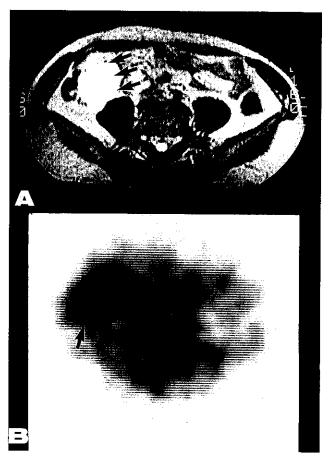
MRI image (A) and SPECT image (B) of patient #2 with recurrent CEA-producing cancer of the small intestine. A large lymph node metastasis is visualized by the CEA102 scintigraphy.
